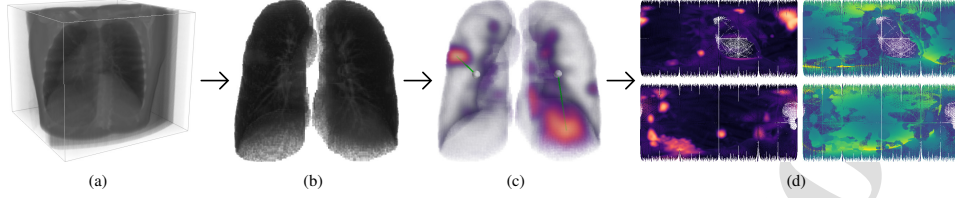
Our omnidirectional imaging strategy: (a) input isotropic chest CT volume; (b) lungs segmentation; (c) estimation of GGO probabilities and positioning of the virtual cameras; (d) construction of the ERP maps with the projection of the maximum GGO probabilities and associated distances for each lung.
